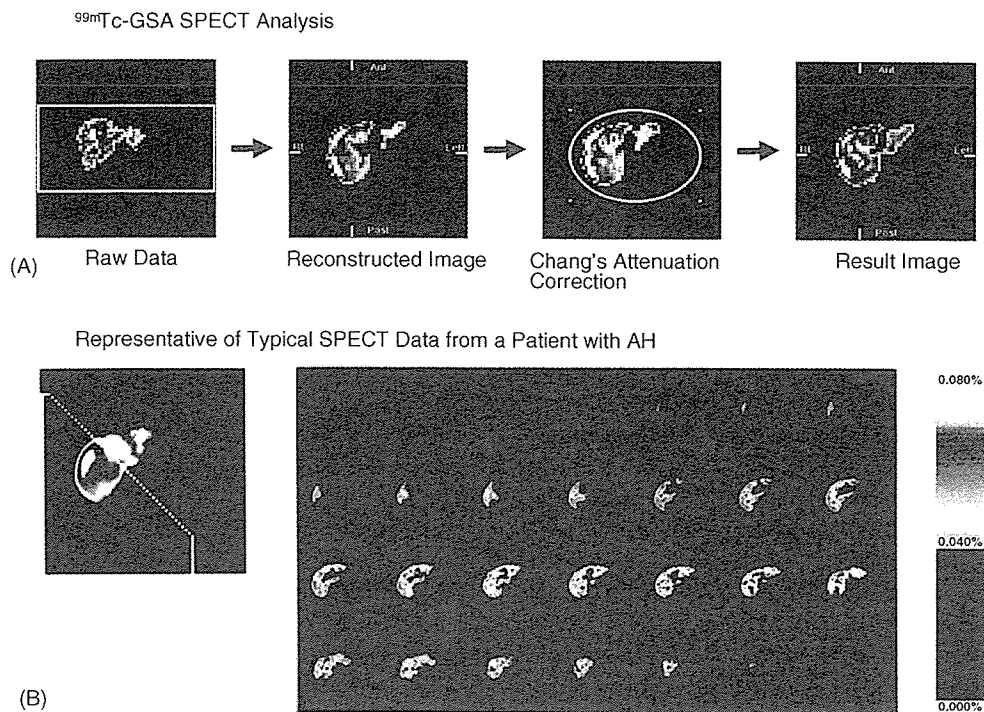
Method used to measure the ^{99m}Tc-GSA counts in the whole liver, and separately in the right and left lobes: (A) SPECT image processing and (B) representative of the typical SPECT data from a patient with AH.
